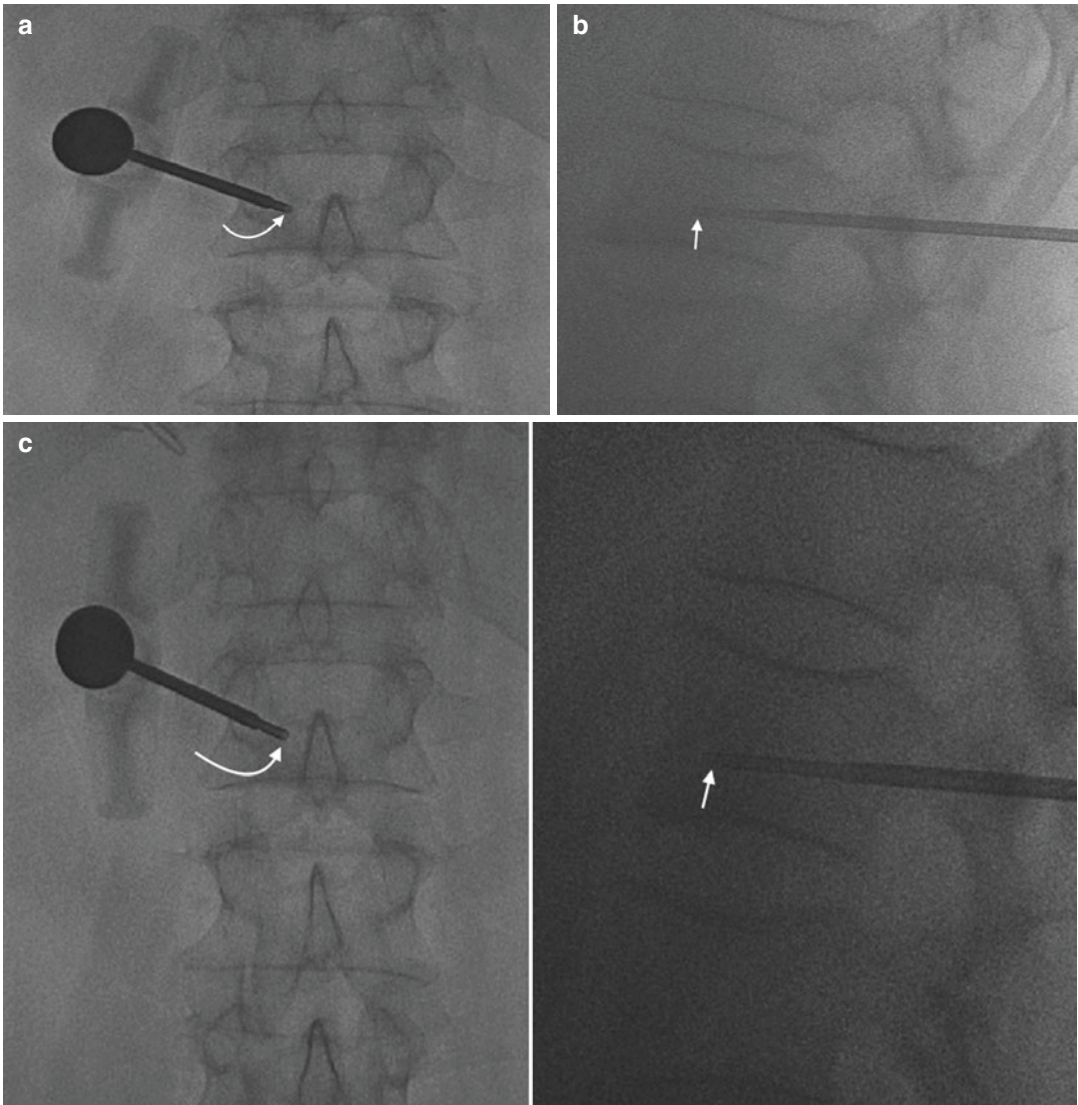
A 76-year-old male with lung cancer and a PET/CT study that showed an abnormal L1 vertebral body. Frontal (a) and lateral (b) fluoroscopic images at the L1 level show coaxial insertion of a 14 gauge bone biopsy needle (*arrows*) through an 11 gauge guide needle (see Fig. 3.15); the 11 gauge guide needle was previously inserted via a transpedicular approach. The bone biopsy needle (*arrows*) was advanced into the anterior vertebral
